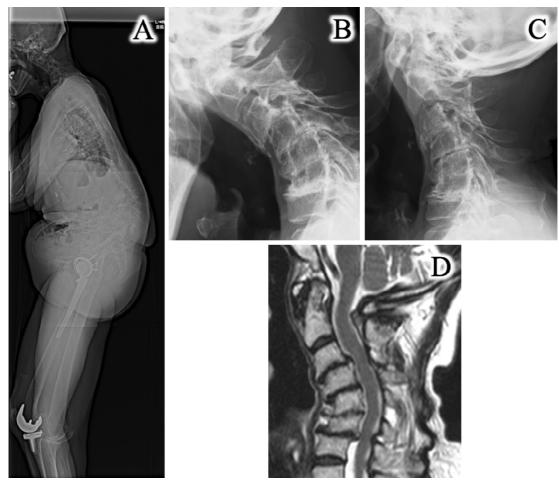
Images before the first operation. (A) An X-ray of the global sagittal alignment of the whole body in standing position. (B) (C) X-rays (lateral view) of cervical flexion and extension. The X-rays show atlanto-axial subluxation, vertical subluxation, subaxial subluxation, and kyphotic alignment. (D) T2-weighted MRI.
